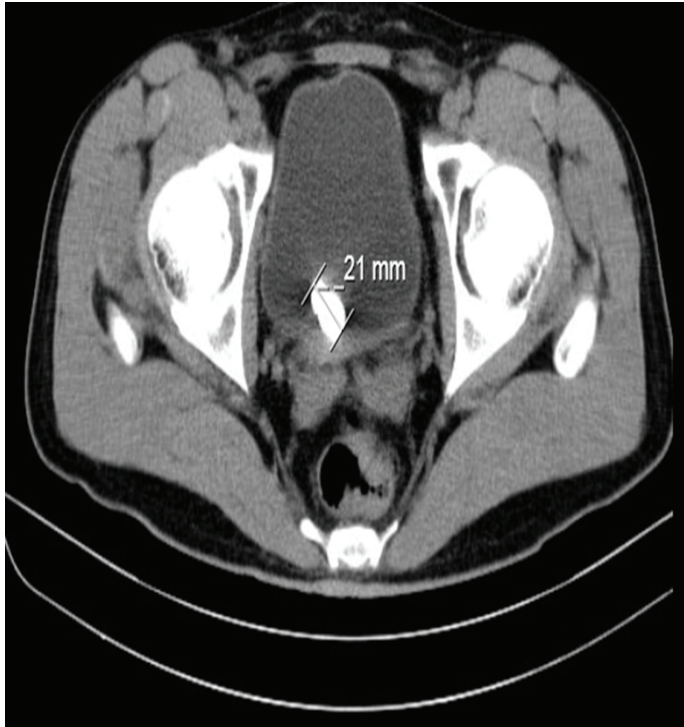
Bladder stone seen on abdominal CT
